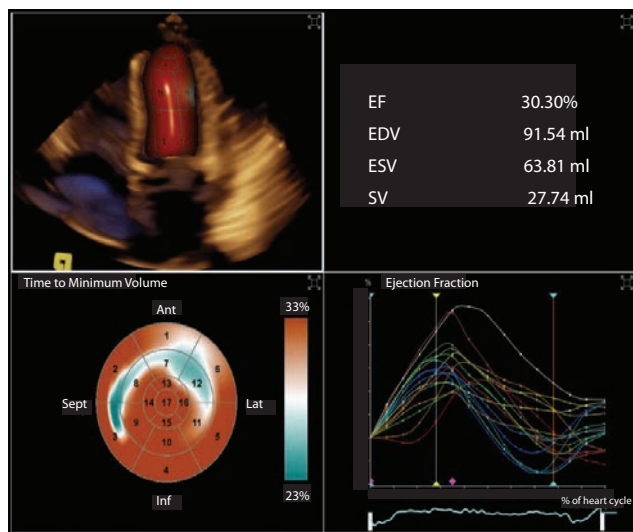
3D transthoracic echocardiography one heart beat - left ventricular (LV) ejection fraction and contraction timing evaluation.
